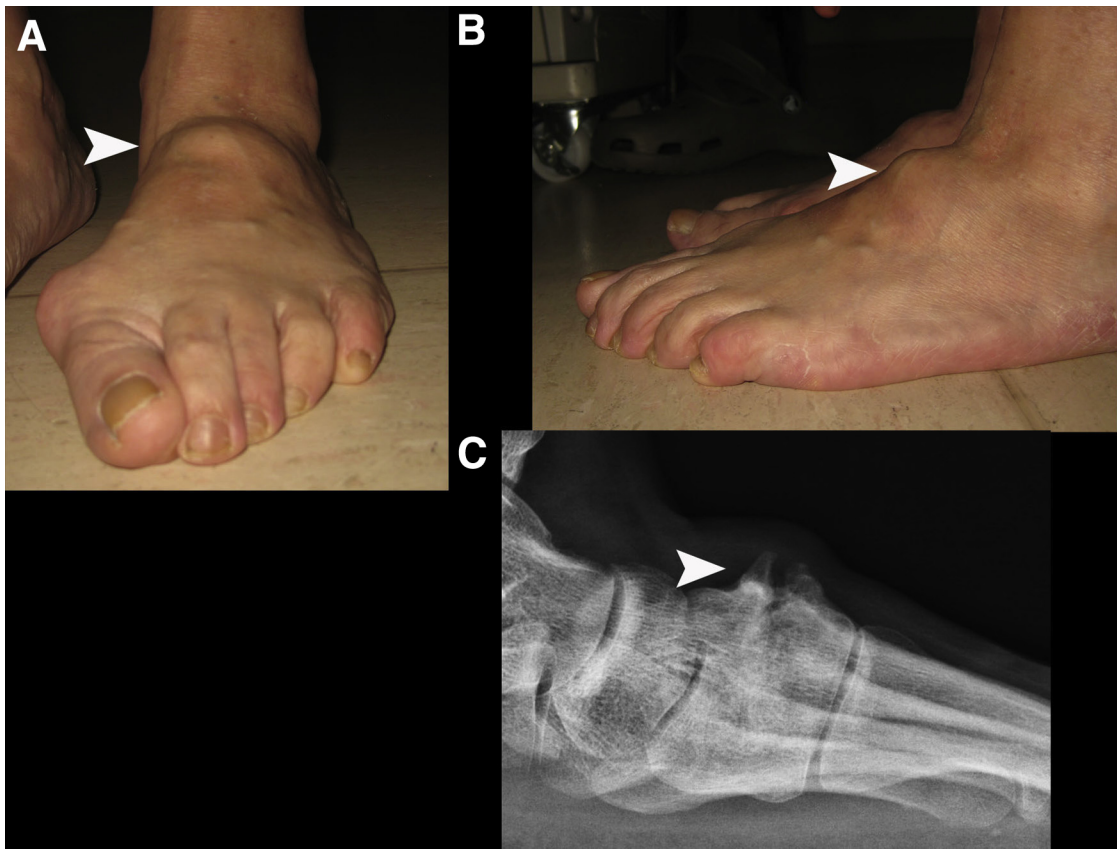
Endoscopic resection of the dorsal boss of the left foot. Anteroposterior (A) and lateral (B) clinical photographs and lateral foot radiograph (C) showed the dorsal boss (arrow).
